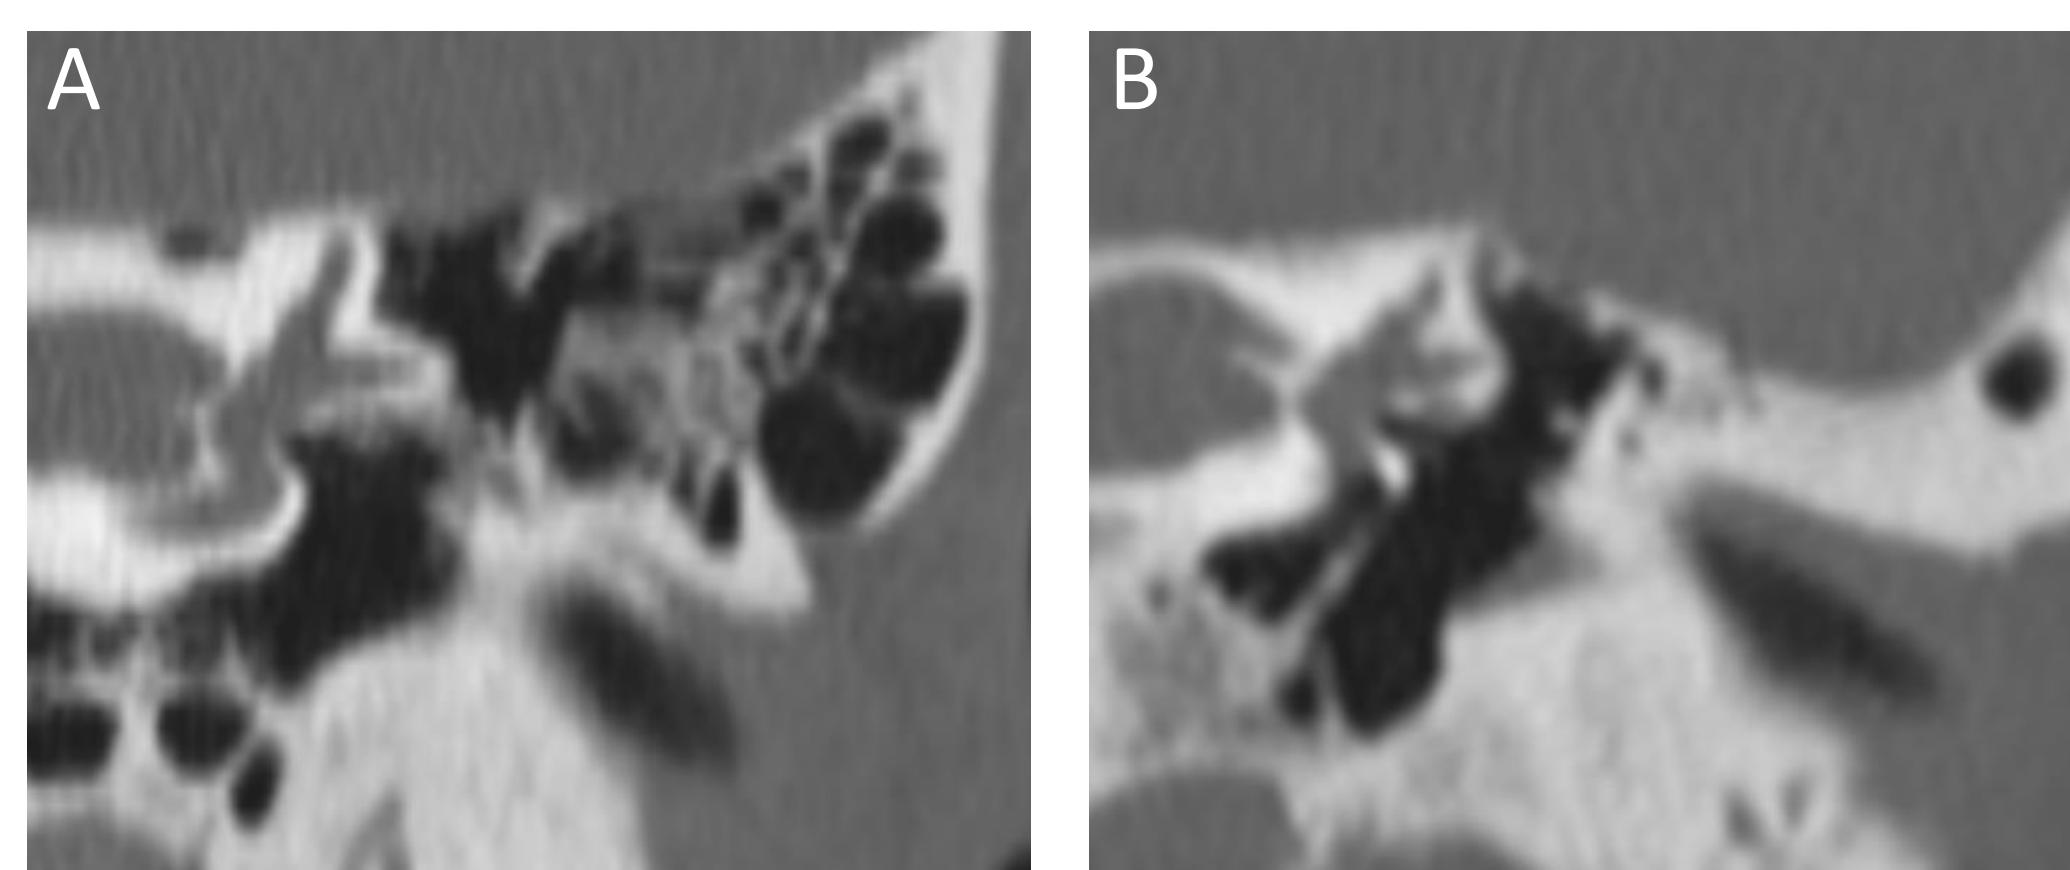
Coronal CT shows normal tegmen height
